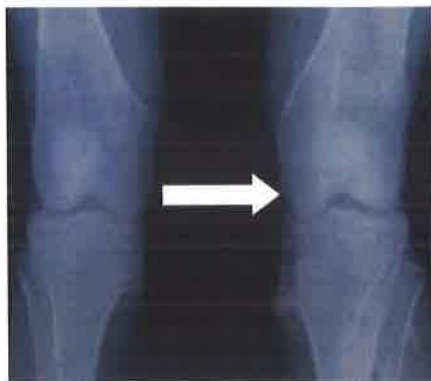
Radiograph ,bilateral Knee : Undertubulation of lower end of bilateral femur(Erlenmeyer flask deformity) with multiple pedunculated exostosis growing away from the joint space (Coat hangers exostosis)
